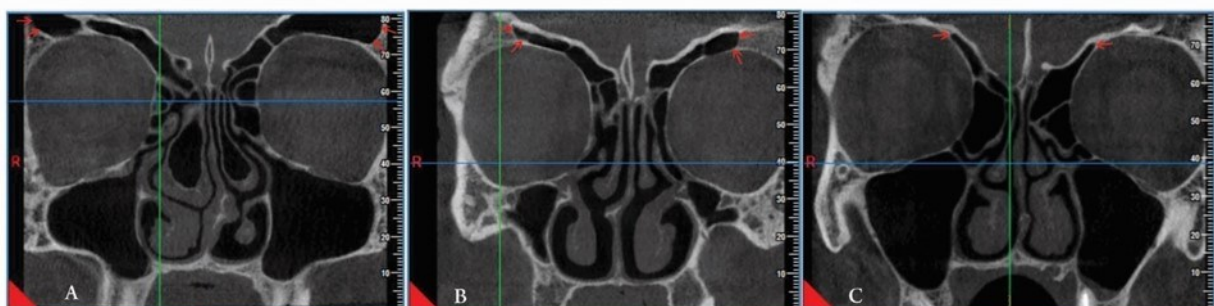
A coronal CBCT cross-section, representing the LFSE to orbital roof at internal, middle and external one-third
